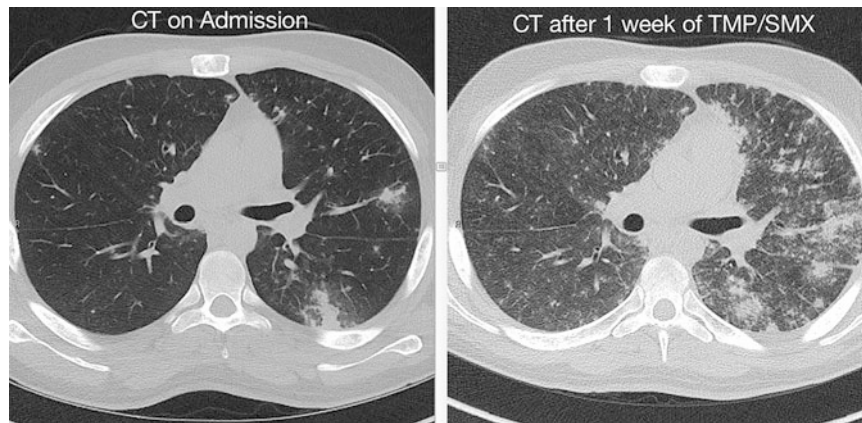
Pneumocystis pneumonia. A 23-year-old man with Ph+ALL s/p matched sibling allo-HCT presented for his 1-year post-transplant visit complaining of worsening fever and cough over the last 2 weeks, despite oral levofloxacin. He was in complete remission. A month earlier, abnormal liver enzymes had prompted the initiation of sirolimus for suspected chronic GVHD. He was on prophylaxis with acyclovir and atovaquone. The CT showed multifocal infiltrates. The bronchoalveolar lavage showed abundant *Pneumocystis*. After 1 week of treatment with trimethoprim/sulfamethoxazole, the radiographic pattern became characteristic of pneumocystis pneumonia. Atovaquone failures are well documented. The radiographic features of PCP after allogeneic transplant may be atypical.
